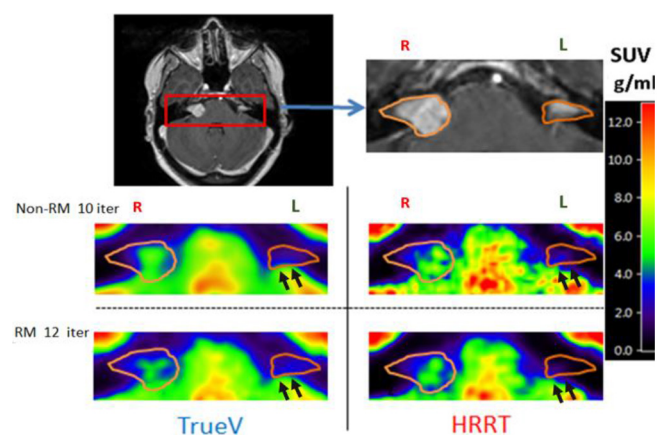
Transverse sections of co-registered contrast enhanced MRI images (top) and FDG SUV uptake images through bilateral VS lesions of patient D for the TrueV (left) and the HRRT (right). Images are shown both without RM (middle row—10 iterations) and with RM (bottom row—12 iterations). For each panel the location of the ROIs used to calculate the values in Table I are shown. PET images are decay corrected to injection time and expressed as SUV (g/ml). Black arrows indicating spill in areas from the brain to VS.
